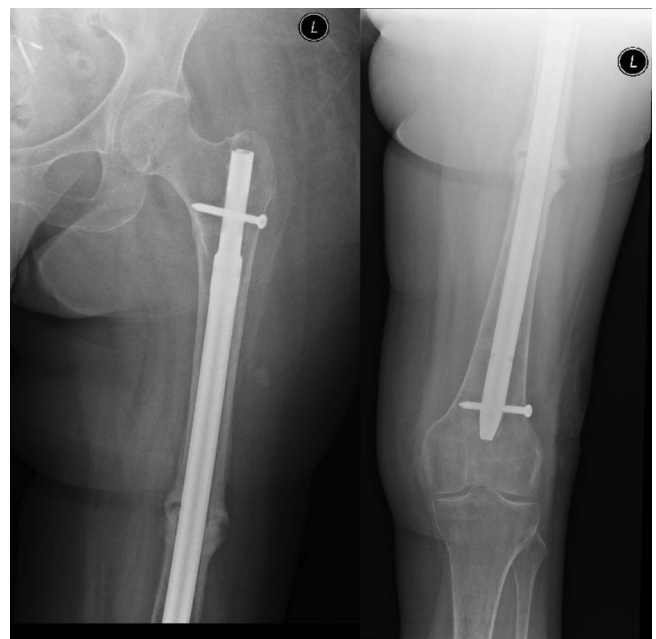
Post-operative radiographs of the left femur showing a femoral intramedullary nail.
